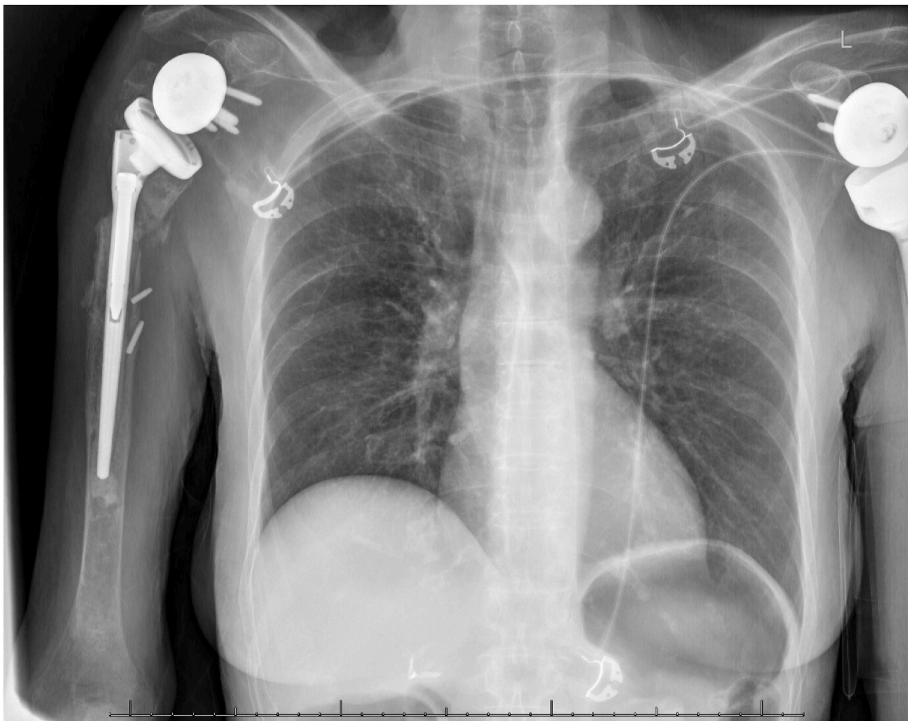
Day 1 chest x-ray on admission.
